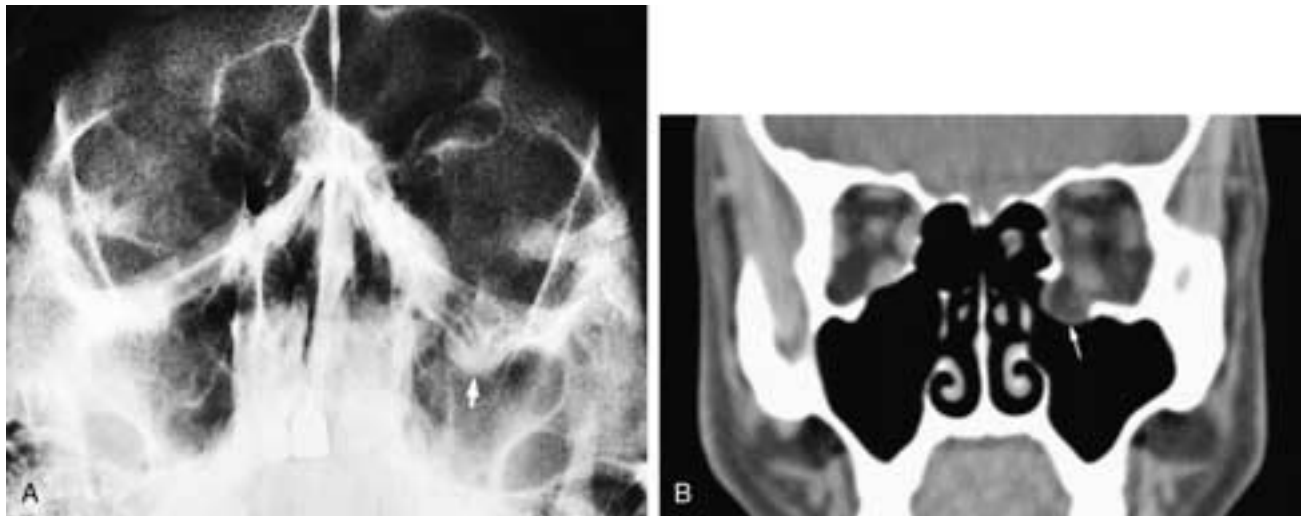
Waters view (A) shows polypoid soft-tissue mass in the roof of the left antrum (*arrow*). This was a blow-out fracture of the orbital floor. Coronal CT scan (B) shows a blow-out fracture of the left orbital floor. The herniated soft tissues (*arrow*) mimic an antral polyp on plain films.
